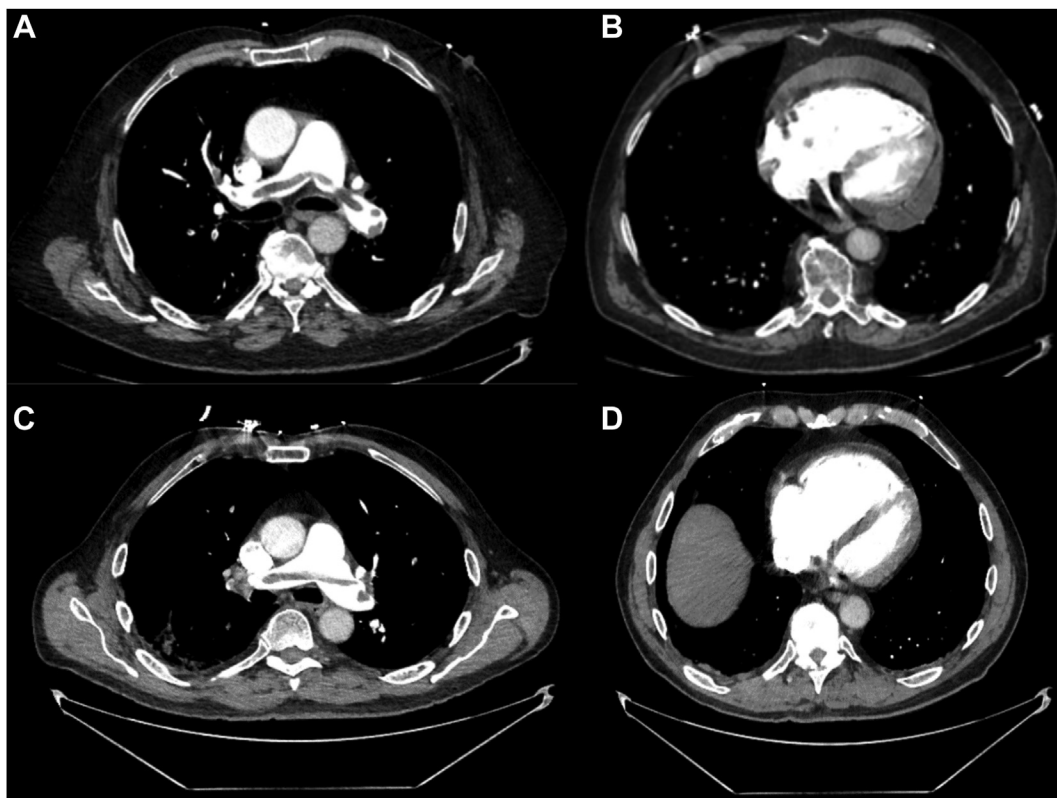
Computed tomography showing saddle pulmonary embolus with an increased right-ventricular-to-left-ventricular ratio in (A, B) patient 1 and (C, D) patient 2.
